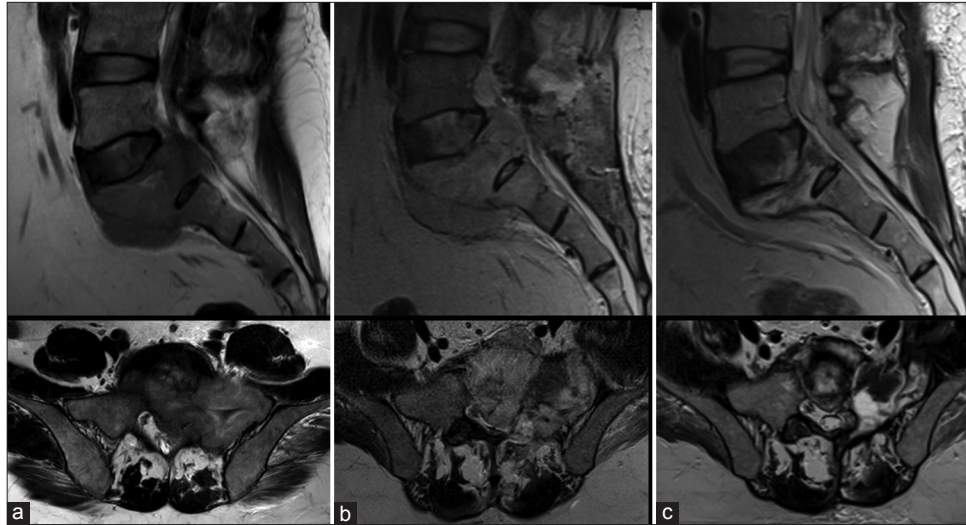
Sequential T2-weighted sagittal and axial magnetic resonance images; (a) Before treatment, (b) At 48 h postmicrowave ablation and (c) 4 months post-ablation. In the initial image before treatment, (a) the lesion is hypointense on images at 48 h and (b) the tumor with a slight increase in its size and a total change in its potency when it became hyperintense; in its control at 4 months, disappearance of the lytic lesion and the soft tissue component can be observed, with a noticeable decrease in the height of the S1 vertebra and formation of sclerotic areas in the bone.
